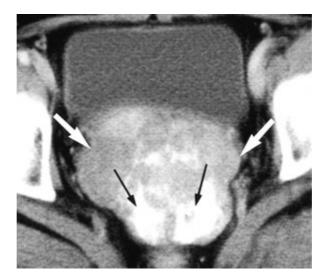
68-year-old woman with Brenner tumor. CT scan shows solid pelvic mass (*white arrows*) with calcifications (*black arrows*).
